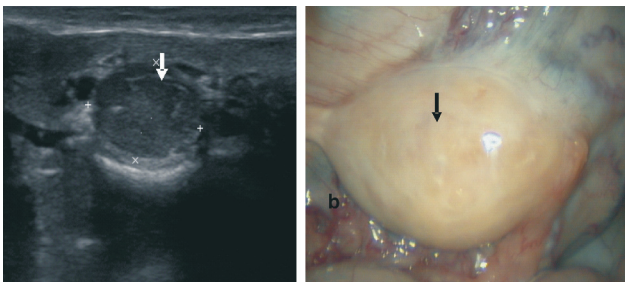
Perioophoritis (arrow). (a) Ultrasound image (b) Laparoscopic image.
